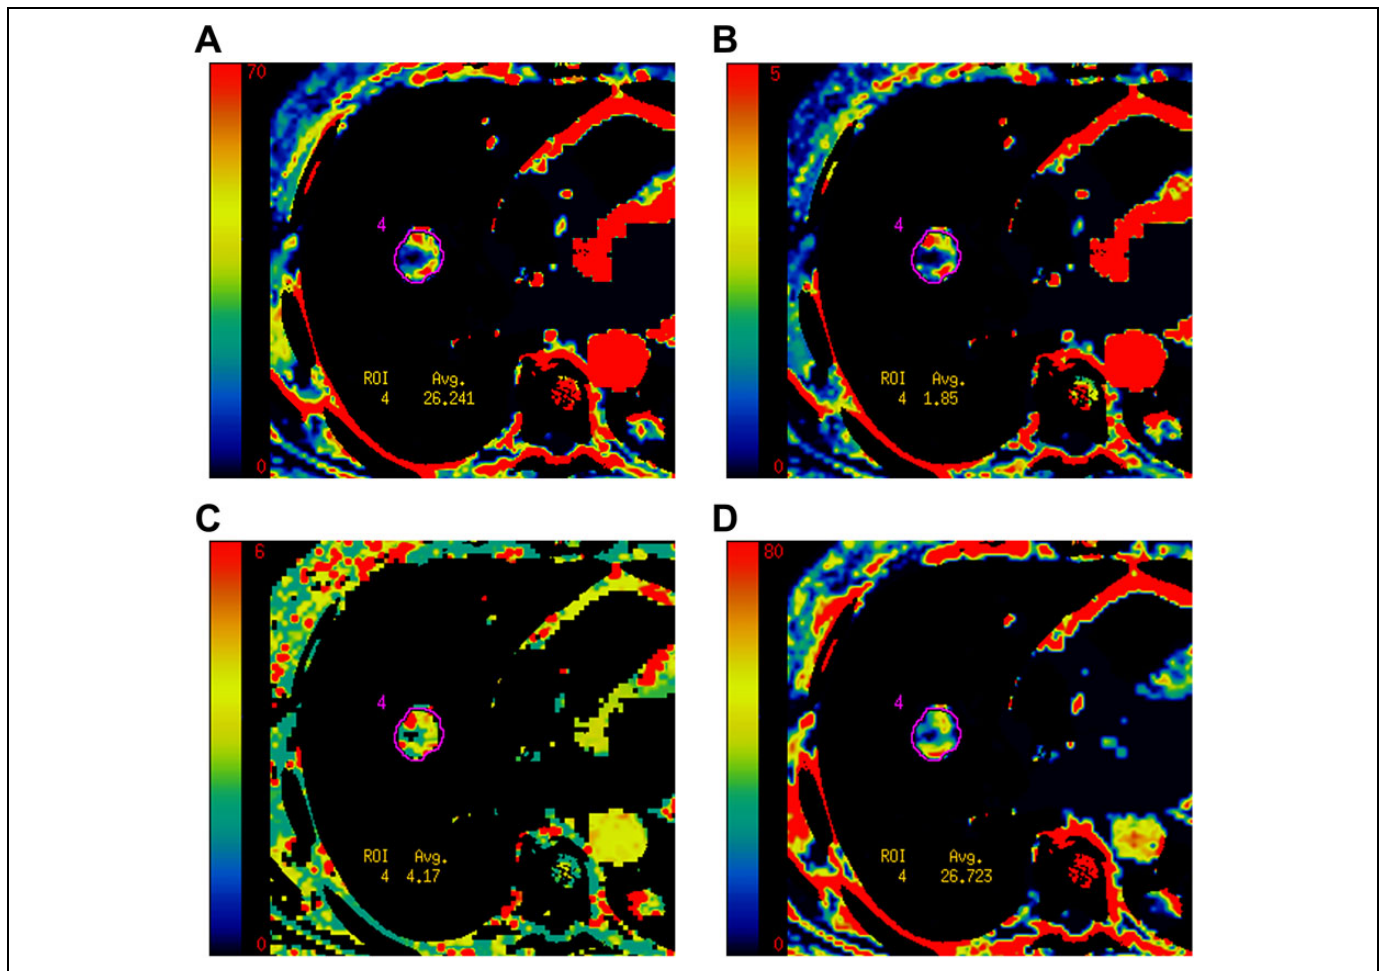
Representative CTP parametric maps for one of the observer combinations of TUM_{roi} and AIF_{roi} at one of the 4 CT slice levels. (A) BF, (B) BV, (C) MTT, and (D) PS. Same patient as in Figure 2. AIF_{roi} indicates arterial input function region of interest; BE, blood flow; BF, blood flow; BV, blood volume; CTP, computed tomography perfusion; MTT, mean transit time; PS, permeability surface area product; TUM_{roi} , tumor region of interest.
